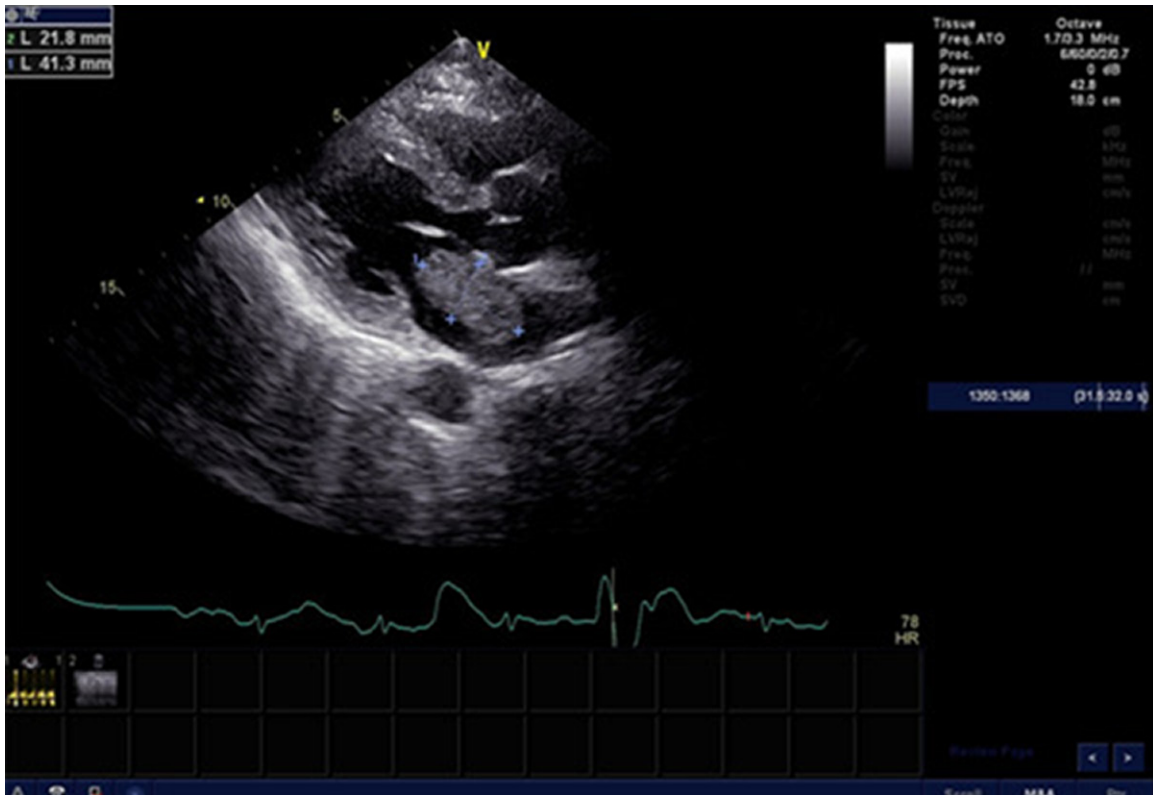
Transthoracic echocardiogram, parasternal long axis, showing a large mass (41.3 mm×21.8 mm) in the left atrium, with a little pedicle attached in the centre of interatrial septum, as slight swing during cardiac cycle in the left atrium.
